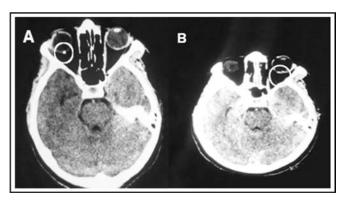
Axial CT Scan (Brain and Orbit) showing focal calcification (round circles) in the posterior globe of left (A) and right (B) eyes respectively.
